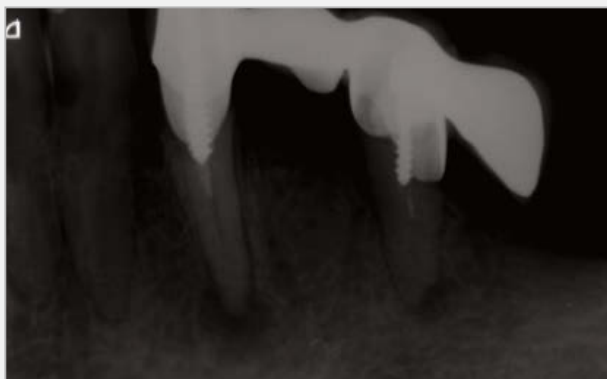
Case 3 - Intraoral x-ray before implant placement.
